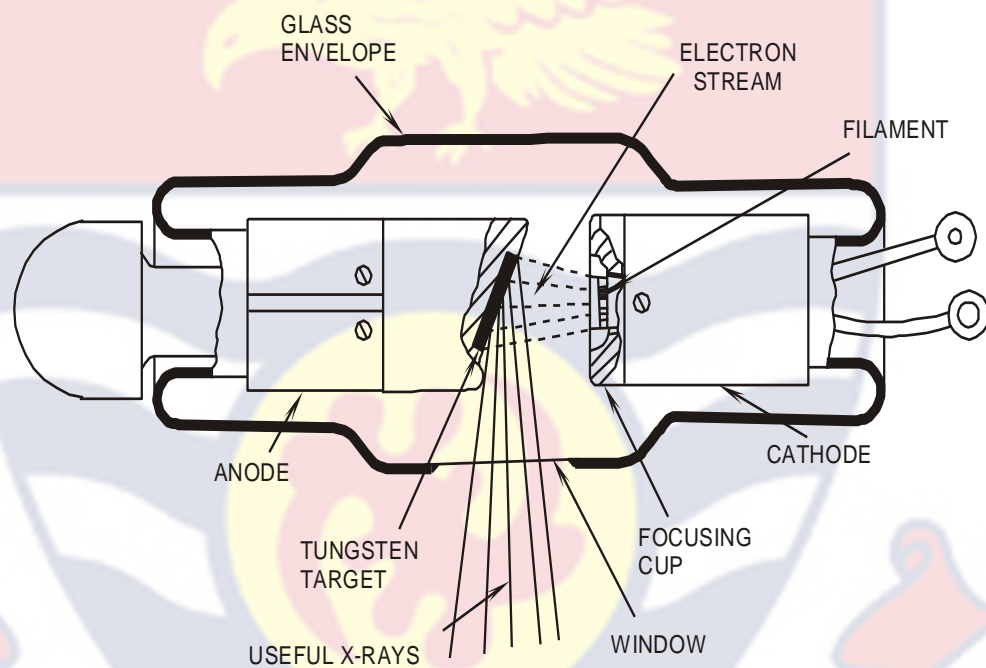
A typical X-ray tube containing evacuated envelope, filament cathode and target anode (Davros, 2007).
